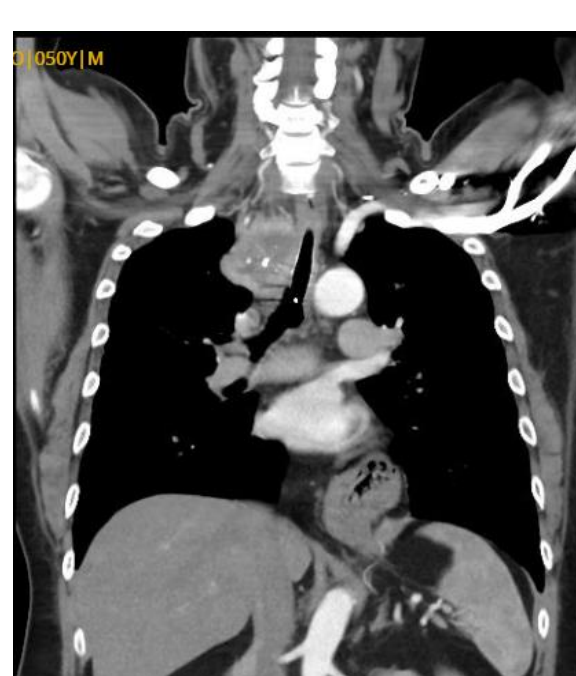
Chest CT scan after Y stent insertion
